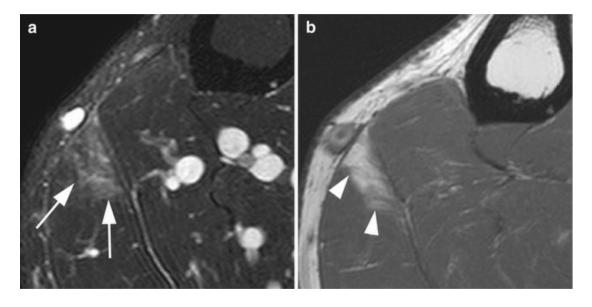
Evolution of muscle injury over time. (a) Axial T2-weighted fat-suppressed MRI depicts circumscribed muscle strain of the medial head of the gastrocnemius muscle as a hyperintense edematous area (*arrows*). (b) T1-weighted spin-echo MRI acquired 3 years later, shows focal fatty replacement in the previously injured area
